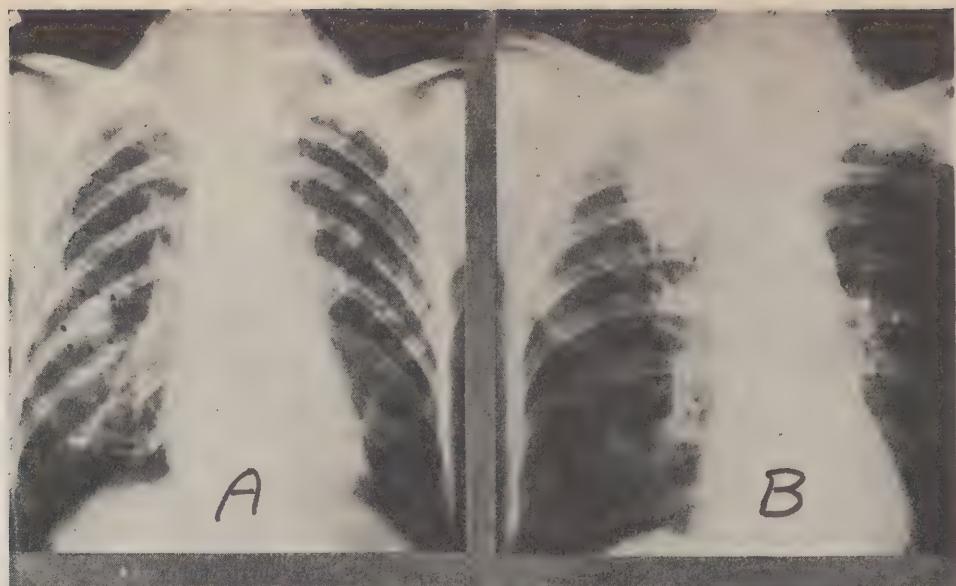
Nine cases of adenocarcinoma. *A*, *B*, *C*, *D* and *E* had symptoms for from one to six months. Each presents a sharply circumscribed, fairly regular, dense mass which is more or less separate from the hilum. *F* had symptoms for eight months. *G*, *H*, and *I* had tumors hidden by the mediastinal shadow. In *G* it was found in the left lower lobe bronchus by bronchography; in *H*, in the left main bronchus at bronchoscopy; in *I*, in the right upper lobe bronchus at autopsy. This radiograph was interpreted to indicate congestive heart failure. Tumor cells were present in bilateral pleural effusions. There were widespread metastases. Autopsy was performed three weeks after this radiograph. Complete removal of the tumor was accomplished in *D*. The patient died from pulmonary edema following thoracoplasty which was done three weeks after pneumonectomy. Autopsy revealed no tumor. *H* is an early radiograph of the case in Fig. 2.
